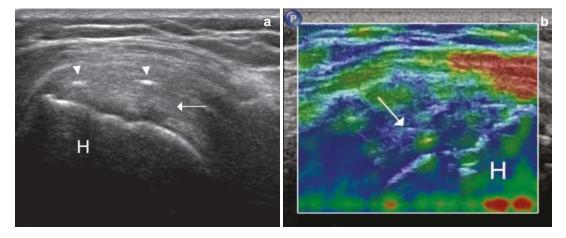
Ultrasound elastography. (a) Longitudinal B-mode and (b) longitudinal axial-strain elastography ultrasound images of a normal supraspinatus tendon post repair (arrows). The tendon demonstrates fibrillated
